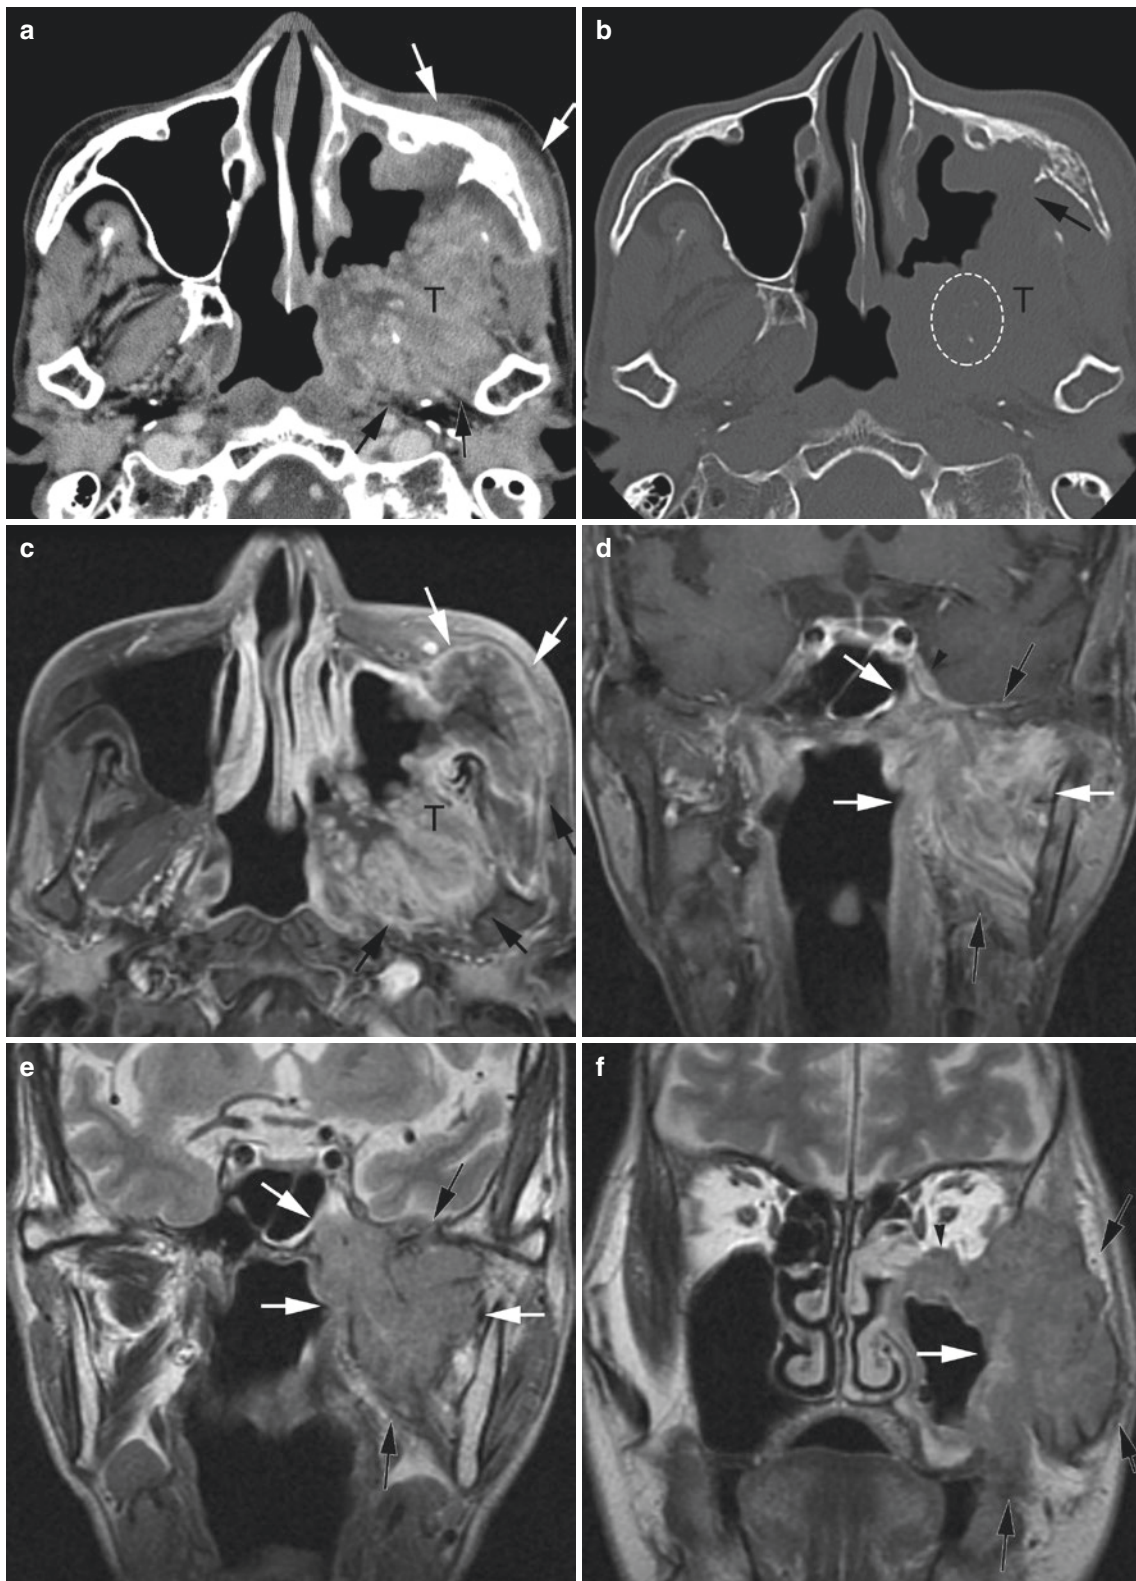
Squamous cell carcinoma of the maxillary sinus. (a) Enhanced CT. (b) Bone algorithm CT. (c) Axial Gd-enhanced T1-weighted image. (d) Coronal Gd-enhanced T1-weighted image. (e) Coronal T2-weighted image. (f) Coronal T2-weighted image (anterior to e). Axial CT scans (a and b) show a mass (T) in the left maxillary sinus massively invading the masticator space with destruction of posterior and lateral walls (arrows). The pterygoid palate is also destroyed (dotted circle). Axial
